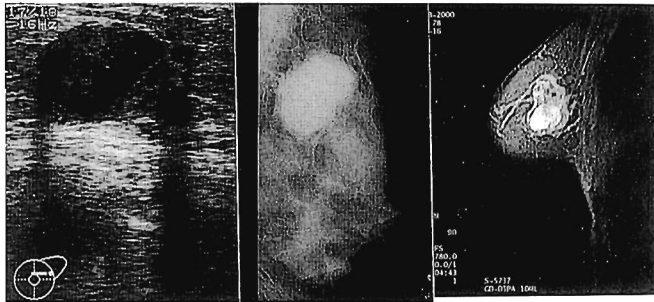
An ultrasonograph of the left breast showing a hypoechoic mass lesion (left), a mammograph revealing an oval tumor lesion (middle) and a T1-weighted MRI demonstrating a high intense, dumb-bell-shaped tumor lesion (right).
